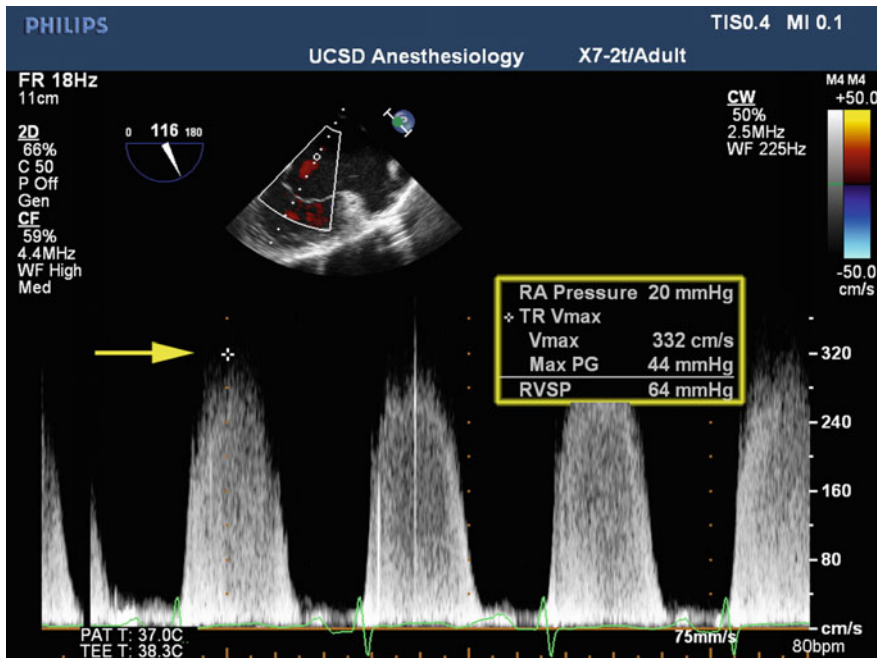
Continuous wave Doppler of the tricuspid regurgitation jet in a modified bicaval view. Applying the modified Bernoulli equation to the peak TR jet (yellow arrow) yields an estimation of right ventricular and pulmonary arterial systolic pressure
